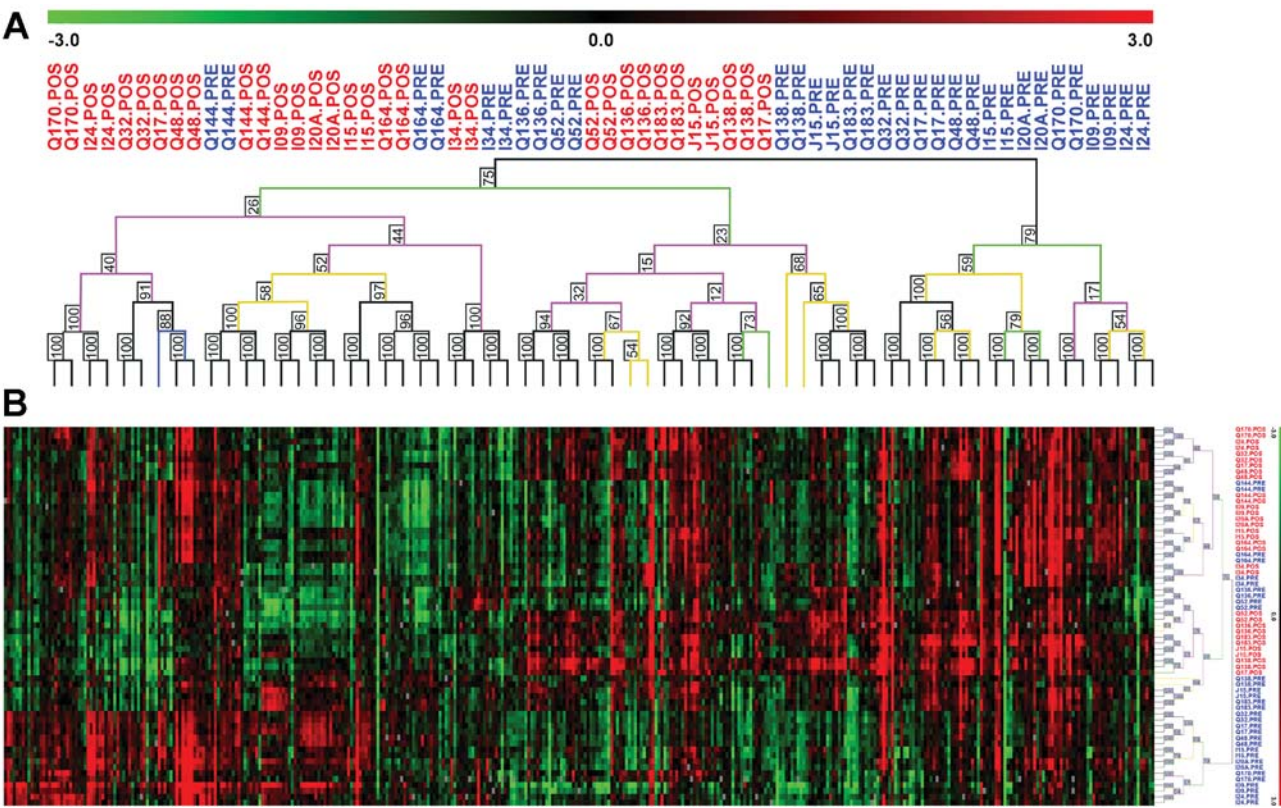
Unsupervised hierarchical clustering of pre- and post-chemotherapy samples. (A) Tumor identification (I, J, Q) appears at the top of the figure, Pre-CT sample (blue) and Pos-CT sample (red). Colored lines of the dendrogram and numbers stand for the support for each clustering, black and gray, more reliable; yellow and red, less reliable. (B) Sixteen paired samples had gene expression evaluated by cDNA microarray. Experiments were made in duplicate (dye swap) and each line represents a tumor sample. Gene expression is represented on columns and the colored bar on the right hand side indicates gene expression variation in target samples as compared to reference cells (HB4A), i.e., red, more expressed and green, less expressed in target samples. Two clusters are clearly seen.
